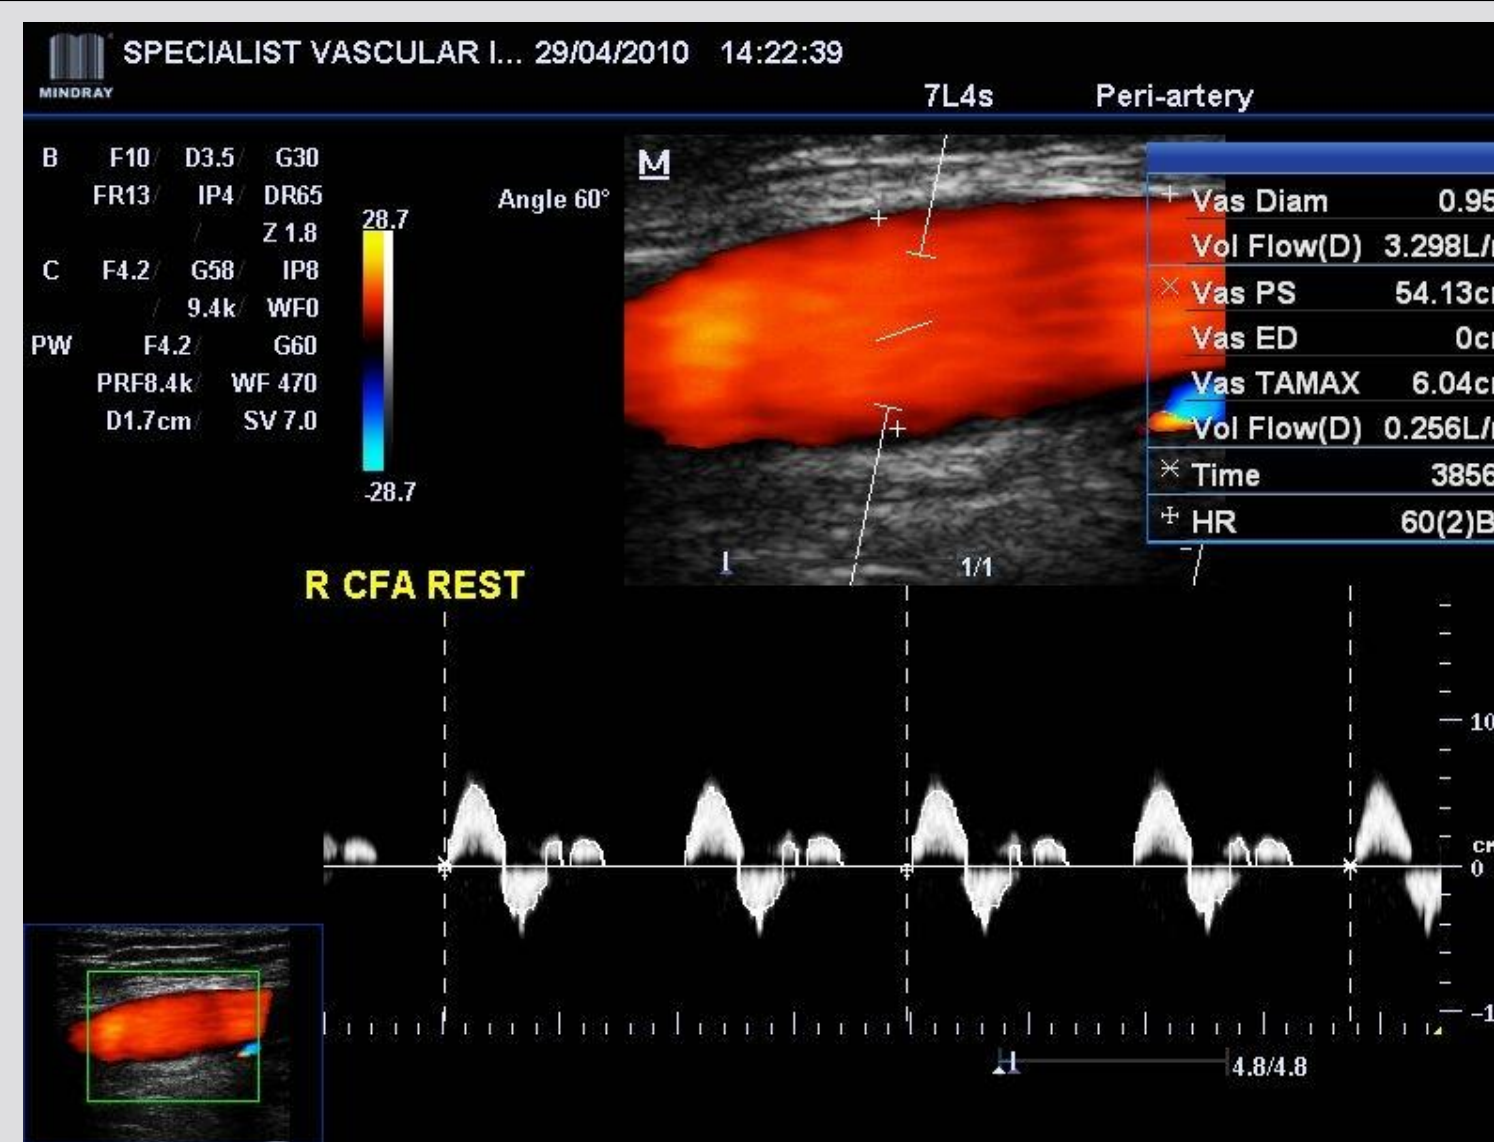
Duplex ultrasound image of femoral artery blood flow at rest
